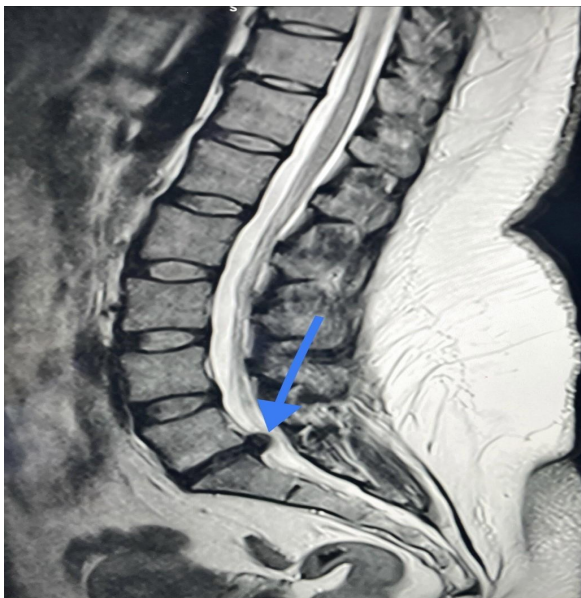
MRI - sagittal section with visible herniation of the intervertebral disc L5/S1 with compression of the thecal sac, resulting in L5/S1 stenosis.
